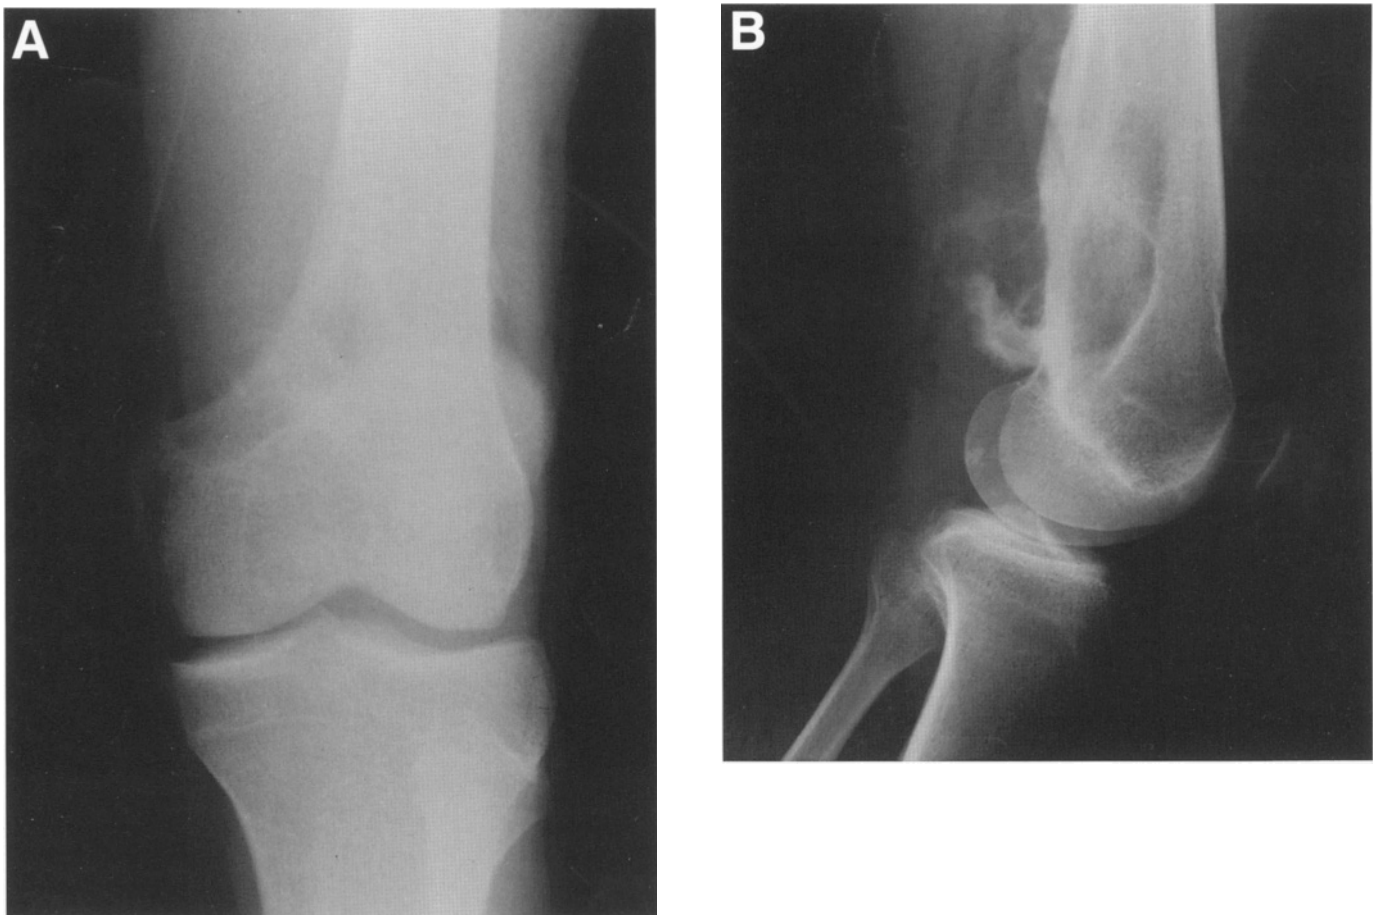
Plain radiograph showing a large osteolytic osteosarcoma arising from the posterior medial aspect of the distal femur. The distal femur is the most common location for osteosarcomas. A purely osteolytic lesion represents approximately 25% of all osteosarcomas. Most radiographic studies underestimate the extent of these lesions. (A) Anterior–posterior view of distal femur; (B) lateral view showing a large posterior component.
